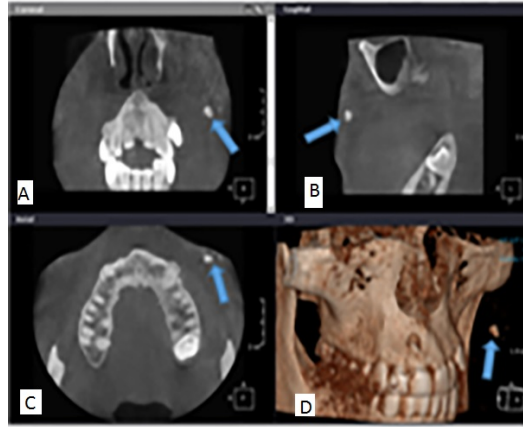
Nodule-shape osteoma cutis measuring 3x6mm in the cheek. The arrows points to the radiopaque lesion in the coronal (A), sagittal (B) and axial (C) plane as well as in the 3D reconstructed image (D), which is diagnosed radiographically as an osteoma cutis.
